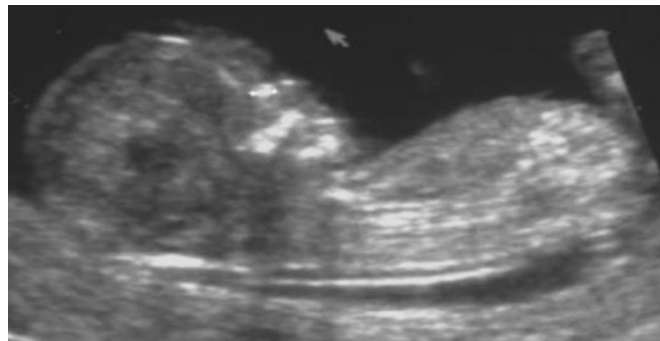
Sonographic measurement of the nasal bone using electronic calipers positioned from outer edge to outer edge ⁽¹⁰⁾
